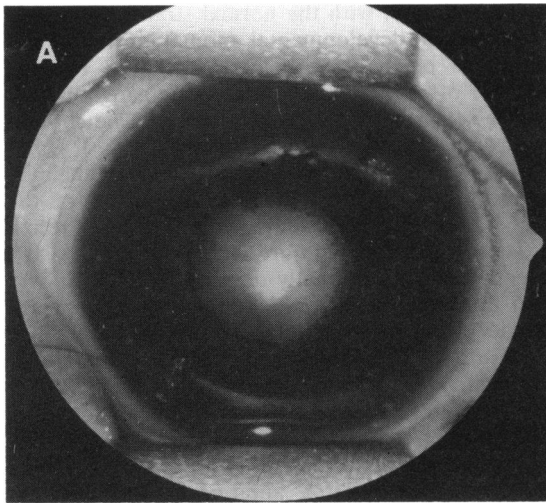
(A) Retrolental vascularised mass. (B) Ultrasonographic demonstration of the retrolental opaque mass. Left eye.
